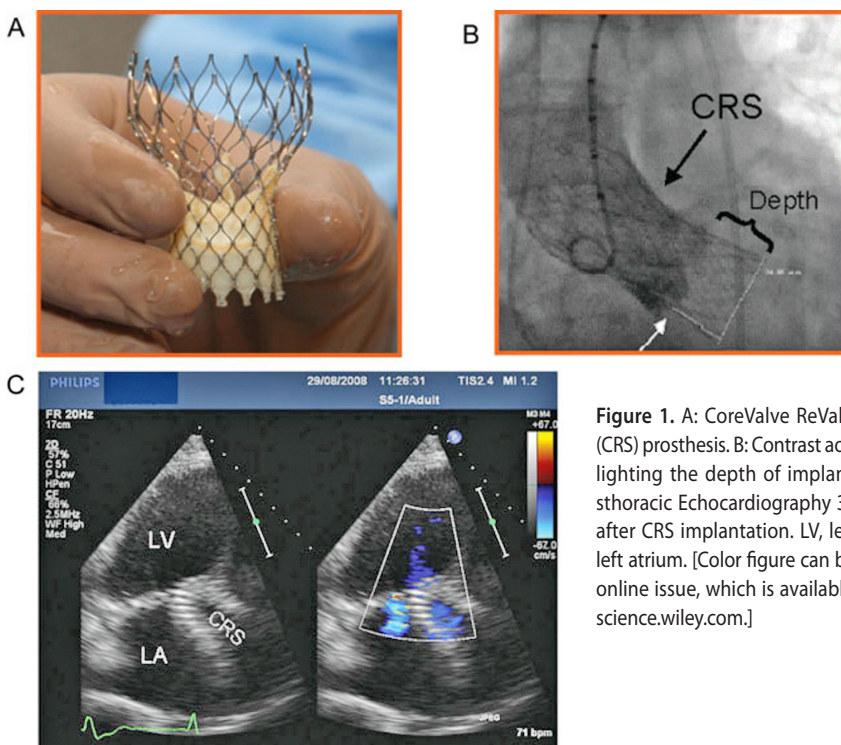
A: CoreValve ReValving System™ (CRS) prosthesis. B: Contrast aortography highlighting the depth of implantation. C: Trans-thoracic Echocardiography 3-chamber view after CRS implantation. LV, left ventricle; LA, left atrium. [Color figure can be viewed in the online issue, which is available at www.interscience.wiley.com.]
